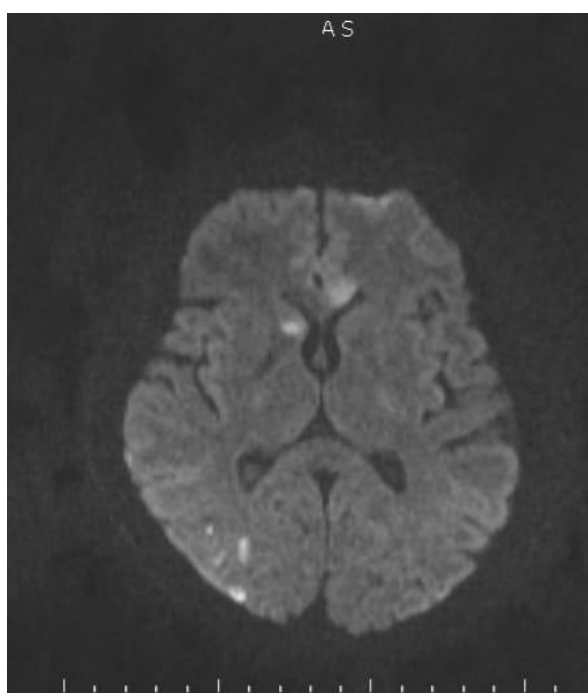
Regions of intracerebral occlusion on MR image sections- occipital and frontal lobes
